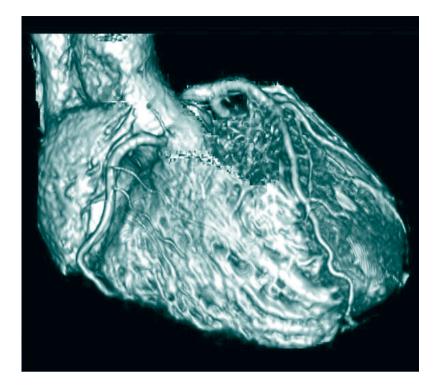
3D MRI image of the human heart, showing the aorta and coronaries.
